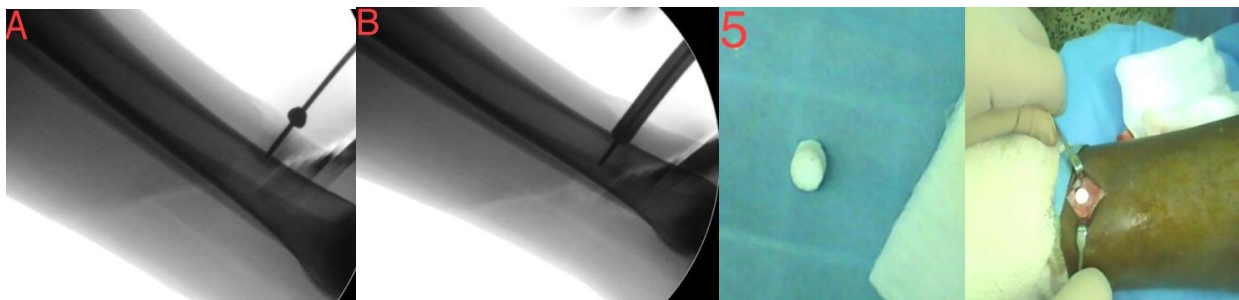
(A) X-Ray image guidance for guide pin, (B) X-Ray image shows hollow reamer, Figure 5. Image of filling the gap with a bone graft
